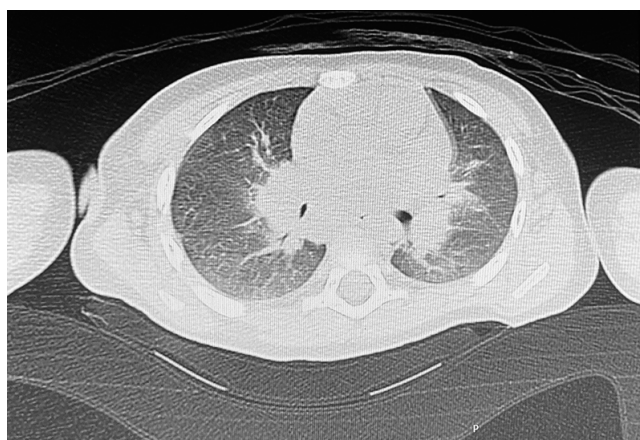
CT of the chest – pulmonary window. Visible thickening in the hilar area and enlargement of mediastinal lymph nodes
